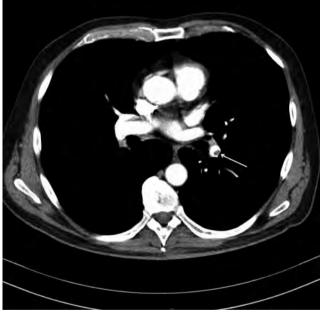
Eccentric filling defect within the left lower lobe artery visualized on an axial CT image – Qanadli Score 5.
